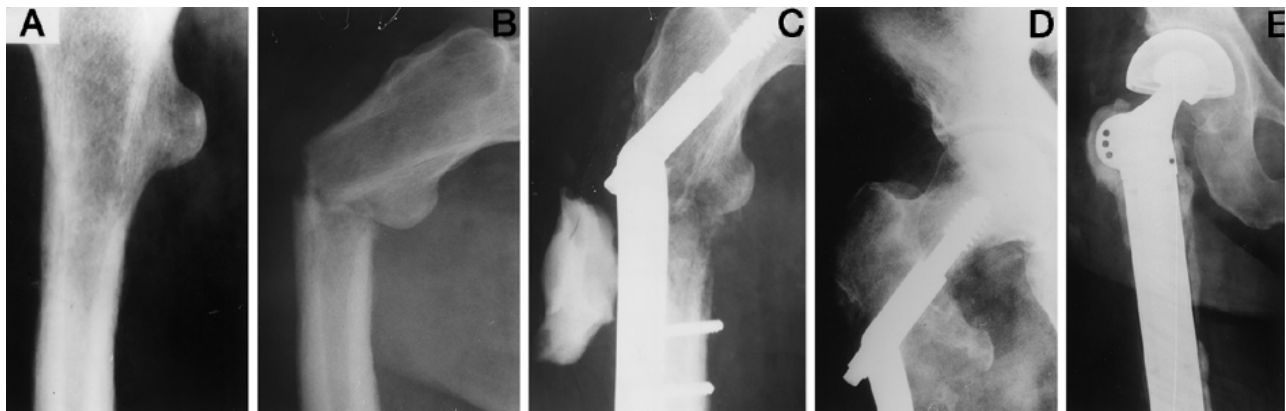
a Radiograph showing a subtrochanteric lytic area with poorly defined edges. Pain had been present for 6 months. b Pathological fracture through the lytic area. c One month after operation, the device has failed and the cement is
